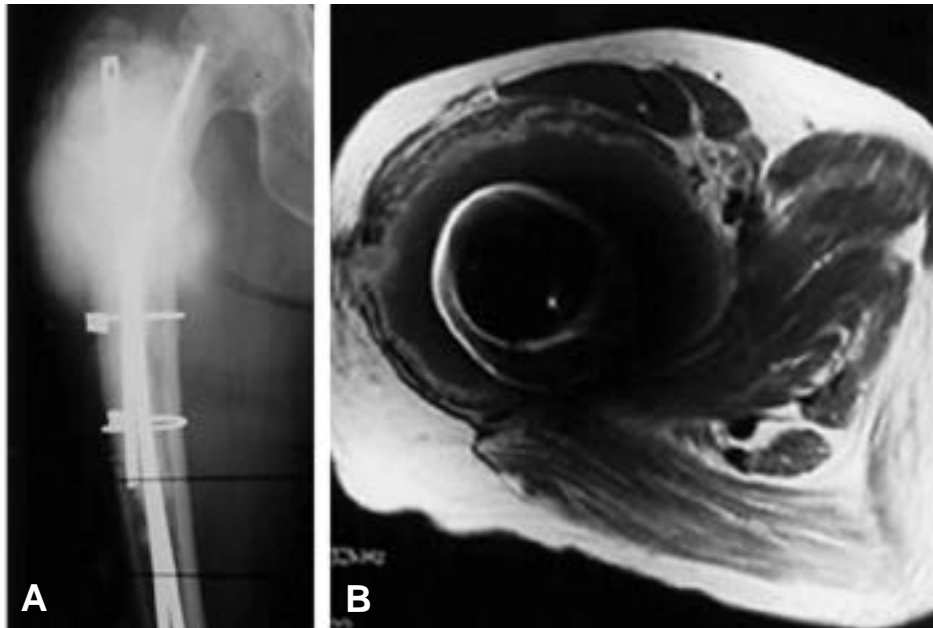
Plain radiograph and MRI show osteoblastic mass in meta-diaphysis of Right. proximal femur with soft tissue extension.
